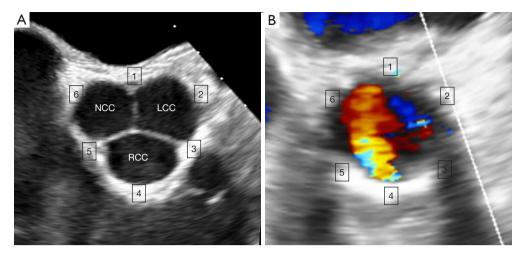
Adapted clock positions around the aortic valve in a short-axis view by transesophageal echocardiography. (A) The normal anatomy of the aortic valve using adapted clock positions, with position 1 corresponding to the traditional 12 o'clock location and position 4 to the 6 o'clock location. (B) A moderate paravalvular leak by color Doppler originating from the mid portion of the RCC at position 4. LCC, left coronary cusp; NCC, non-coronary cusp; RCC, right coronary cusp.
